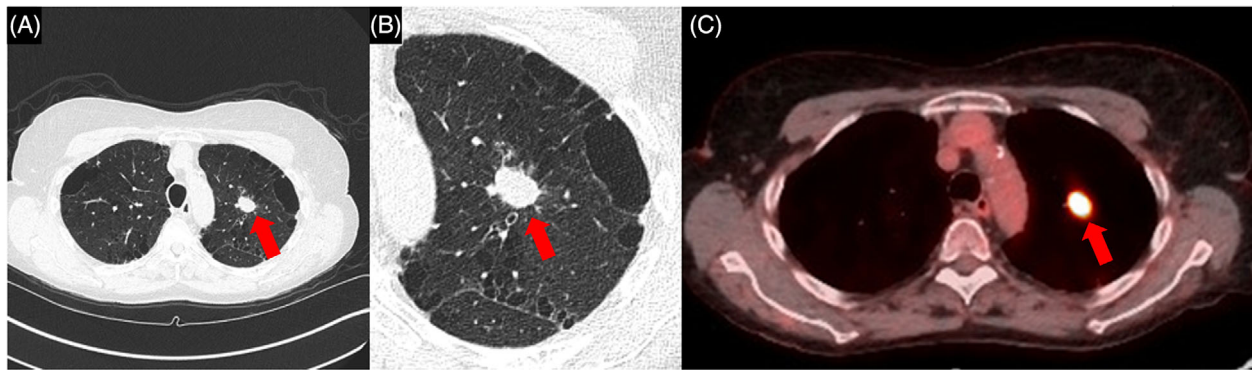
(A) Computed tomography axial view of the 18 × 13 mm nodule in the left upper lobe (red arrow). (B) Close up view of the left upper lobe nodule in chest CT (red arrow). (C) Positron emission tomography scan showing maximum SUV uptake of 18.9 in left upper lobe nodule (red arrow).
